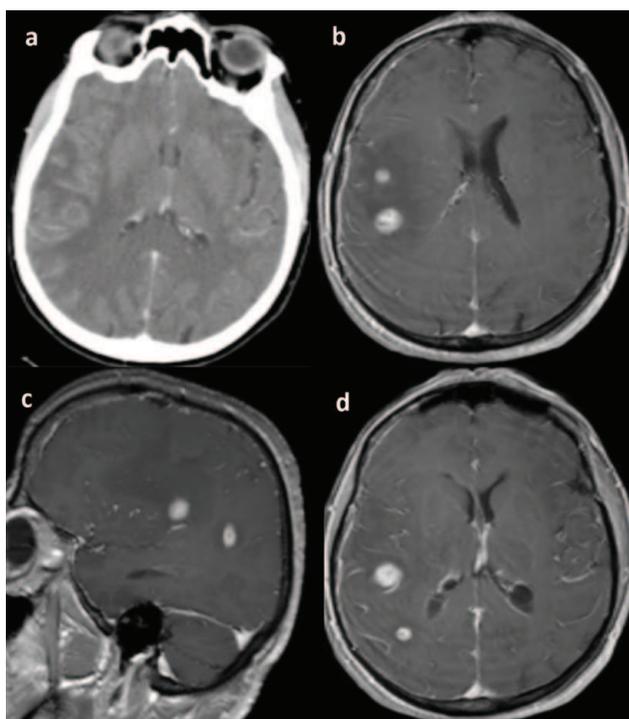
Case 1: 64-year-old female with left hemiparesis and dysarthria. (a) Computed tomography (CT scan), and (b–d) T1 weighted magnetic resonance (MR) with contrast enhancement, showing multiple independent lesions in the right parietal lobe.
